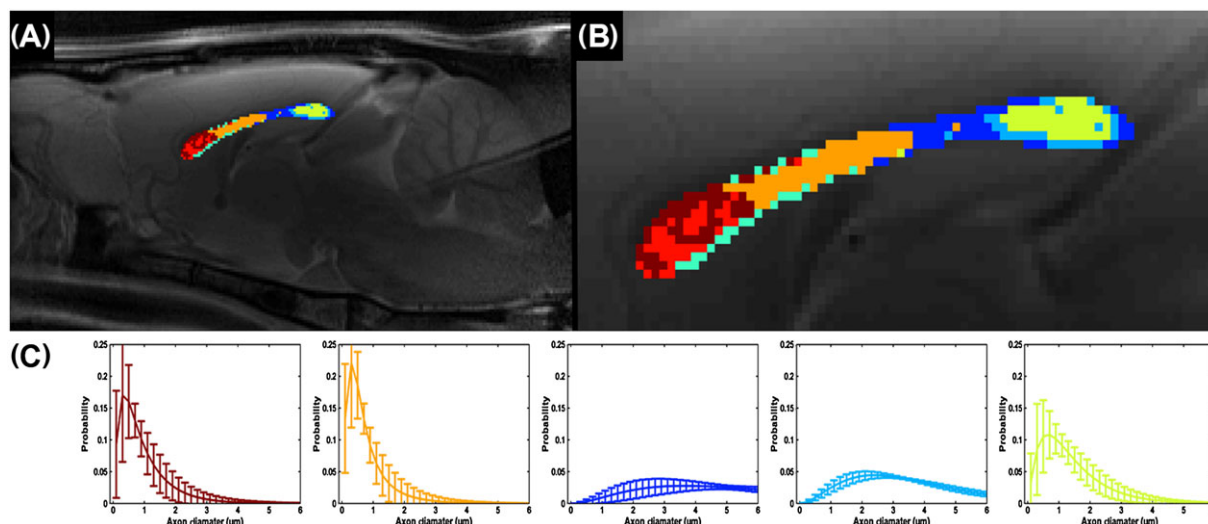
Cluster analysis of AxCaliber's axon diameter distribution (ADD) along the corpus callosum: (A) mid-sagittal T_2 -weighted magnetic resonance imaging with the AxCaliber clusters superimposed; (B) enlarged (A); (C) AxCaliber averaged ADDs for the different clusters given in (A) and (B)
